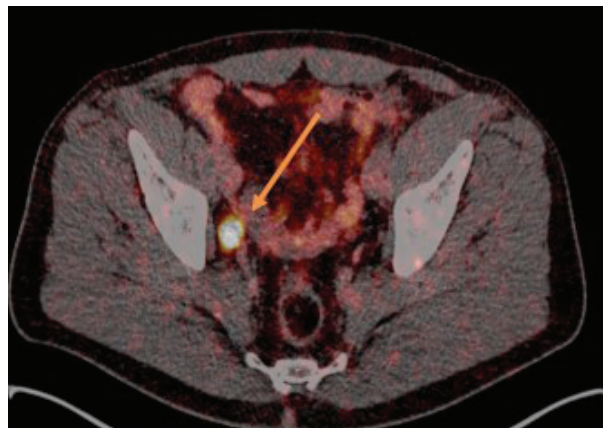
Lymph node metastasis behind external iliac vessels in a patient with PSA 0.21 ng/mL. The patient had a radical prostatectomy 4 years before BCR and PSAdt of only 2 months. SUVmax 45.
